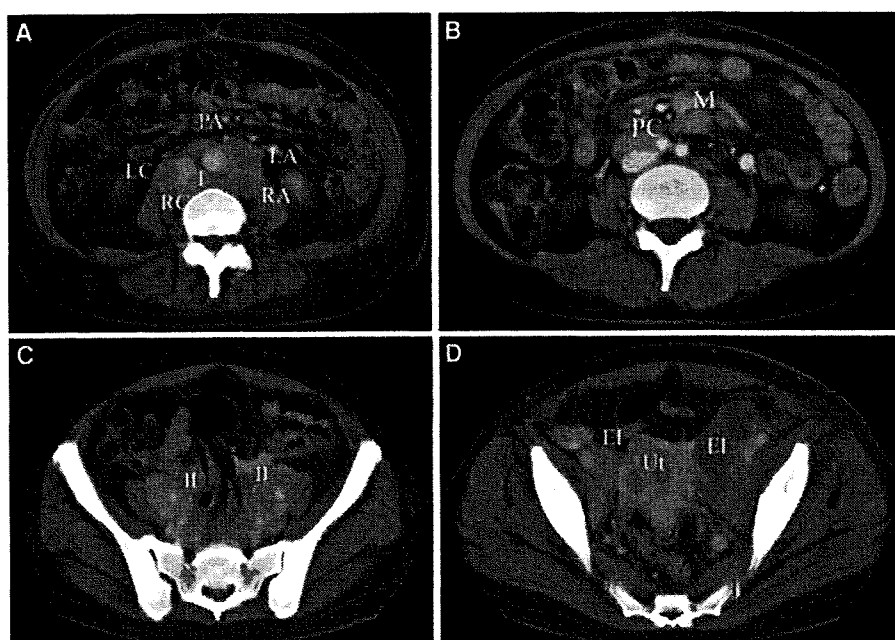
A–D Axial contrast-enhanced CT image shows multiple enlarged lymph nodes in patient with follicular lymphoma. LA, lateroaortic lymph node; PA, preaortic lymph node; RA, retroaortic lymph node; LC, laterocaval lymph node; RC, retrocaval lymph node; I, intermediate lumbar lymph node; M, mesenteric lymph node; II, internal iliac lymph node; EI, external iliac lymph node; Ut, uterus.
